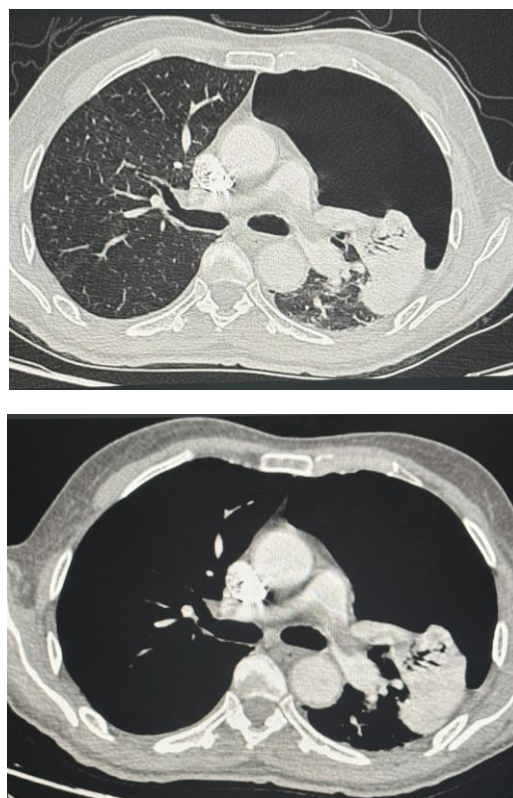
CT pulmonary angiography, from top to bottom. (A) Coronal section showing endoluminal hypodense material in the right and left pulmonary arteries and their segmental branches, consistent with bilateral pulmonary embolism. (B) Axial section in lung window showing a large left pneumothorax. (C) Axial section showing endoluminal hypodense material in the right and left pulmonary arteries and their segmental branches
